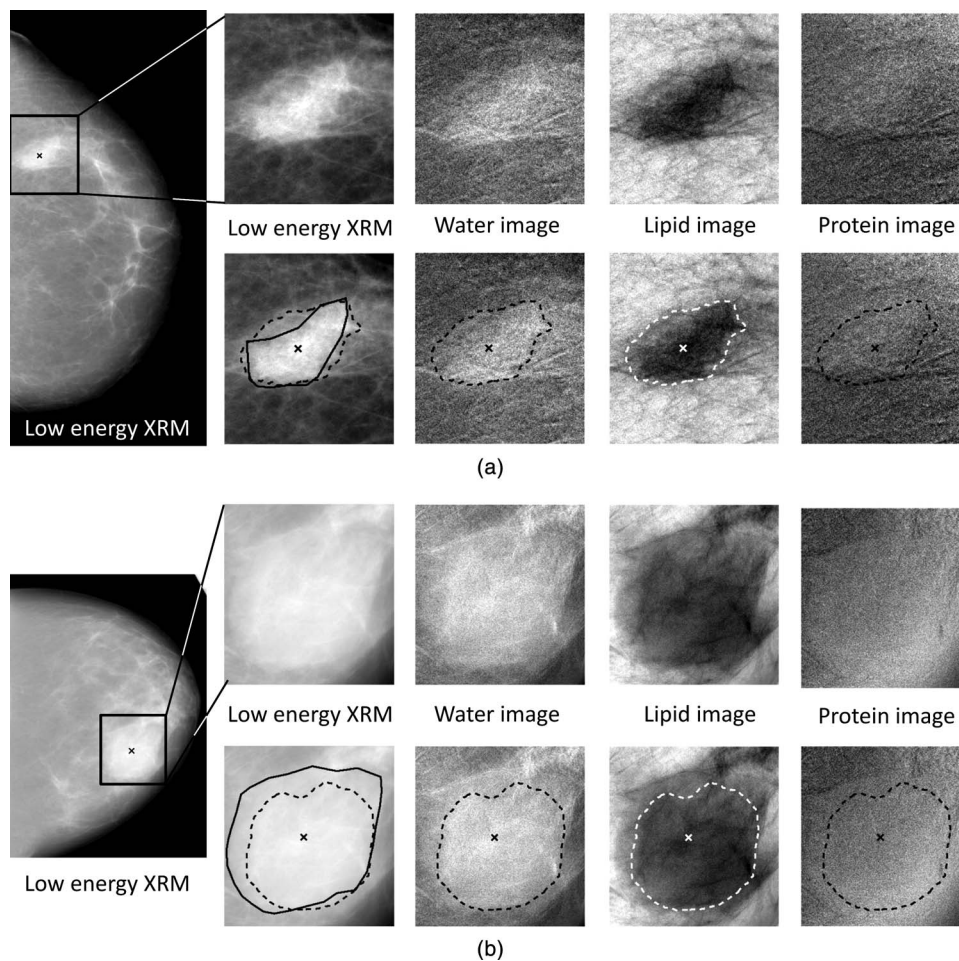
Example images of (a) an invasive ductal carcinoma (IDC) and (b) a fibroadenoma (FA): Full field CC view (low-energy mammogram) and regions-of-interest of the (1) low-energy x-ray mammogram, (2) water, (3) lipid, and (4) protein images without (top) and with (bottom) the computer-determined lesion boundaries (dashed line), radiologist manual outline (solid line, on low-energy mammogram only), and radiologist-indicated lesion center (“x”). Computer-determined lesion boundaries were used in all calculations presented here.
